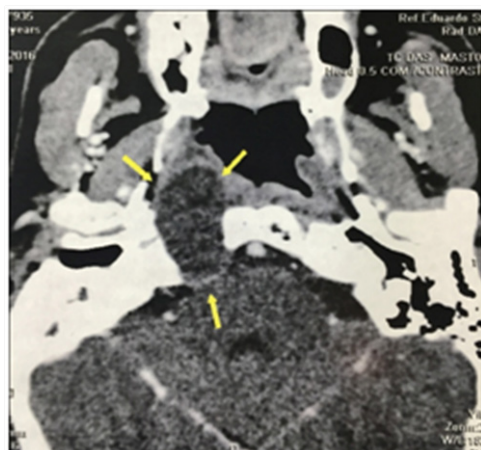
Preoperative axial contrast CT with a right expansile and lytic petrous apex lesion with bony erosion.
